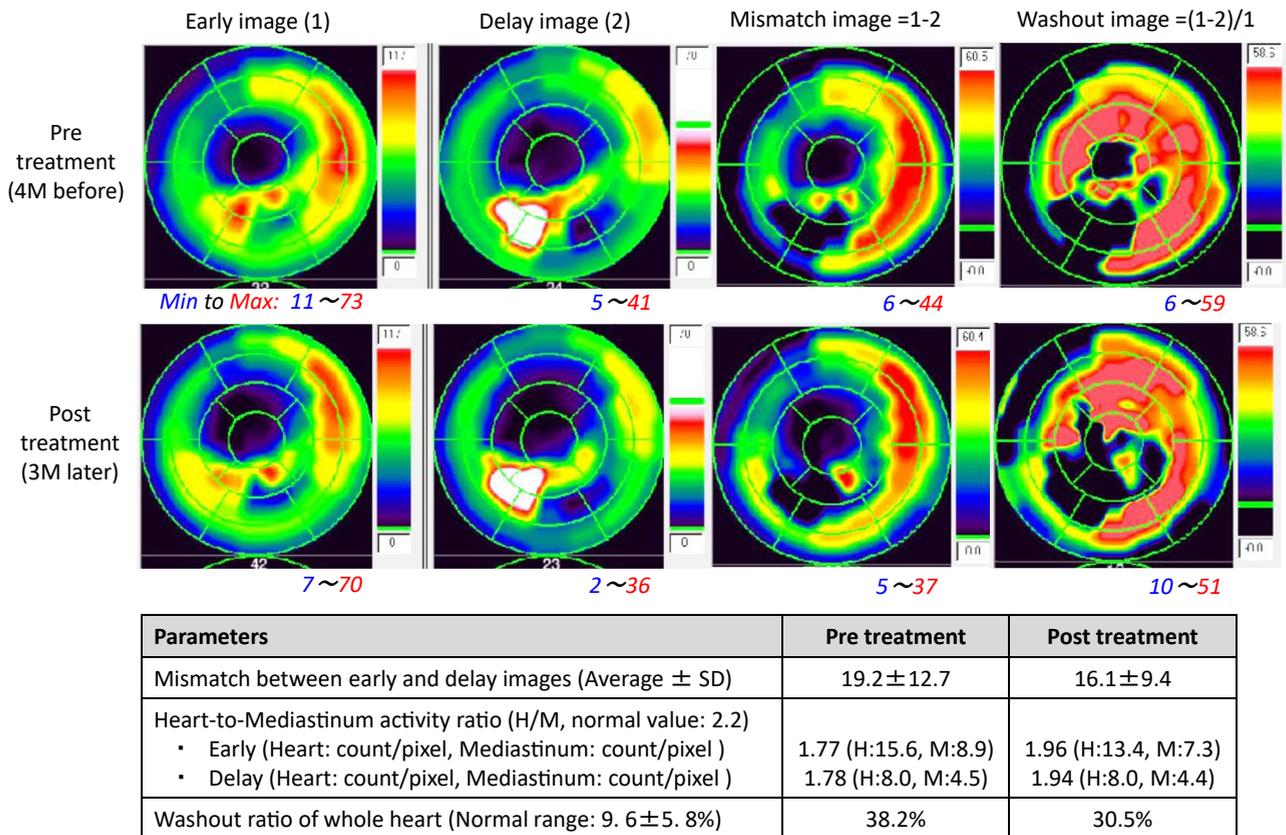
Sympathetic activity. ^{123}I -metaiodobenzylguanidine scintigraphy before and after treatment. The difference between early and delayed (3 hours later) phase provided the mismatch image. Washout images were created by dividing the mismatch image by the early-phase image.
